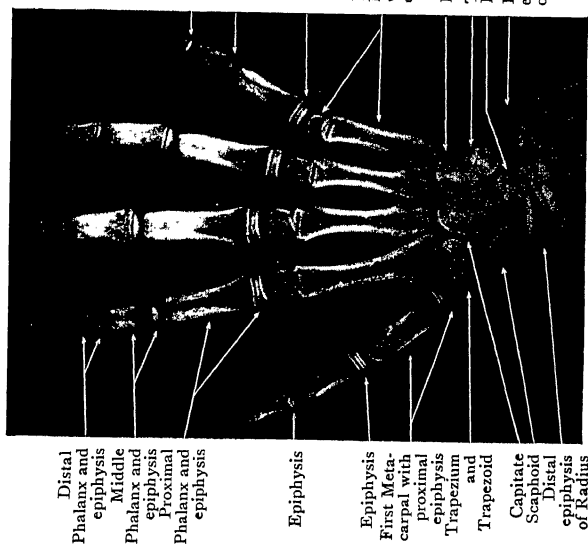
Radiograph of Wrist and Hand of girl aged 7.
